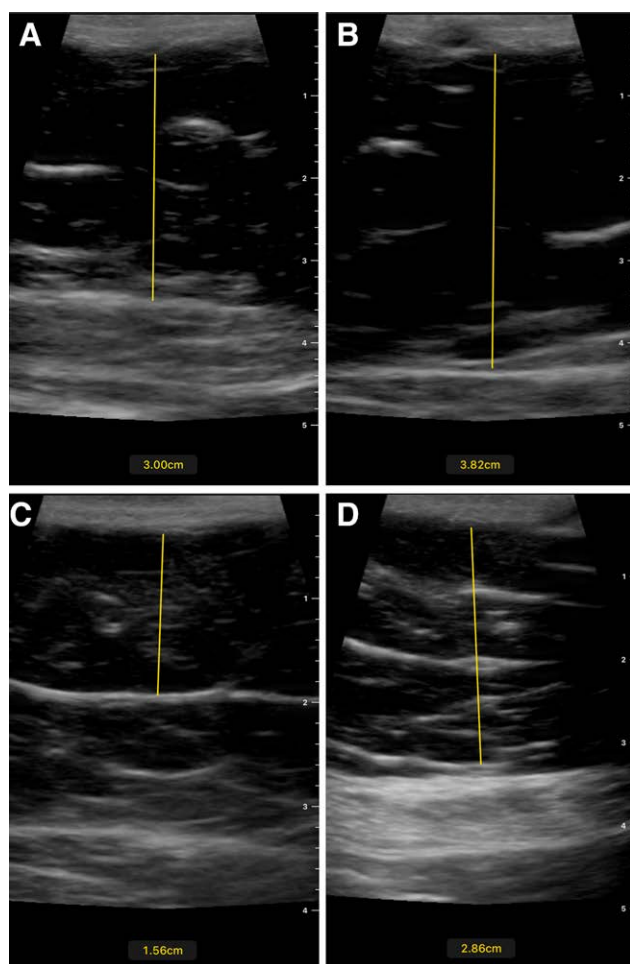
Sonographic images of subcutaneous fat thickness from two treatment locations before and after treatment with the Transform radiofrequency and EMS device. A and B, Pretreatment images. C and D, The corresponding 3-month posttreatment images demonstrating reduction in subcutaneous fat thickness.
